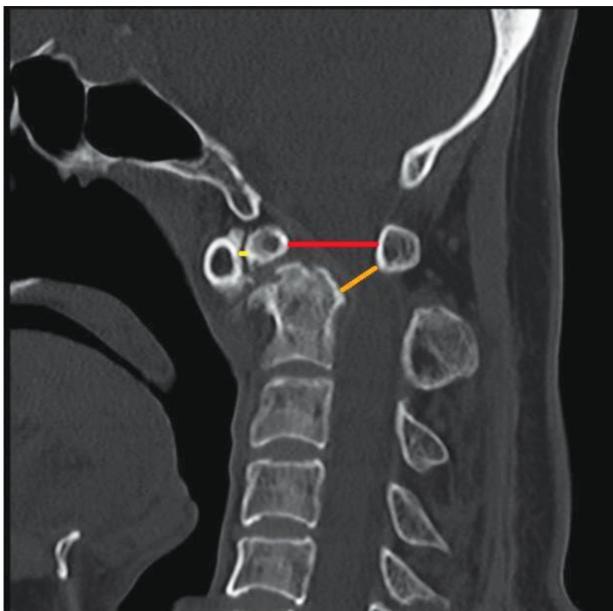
Radiographic parameter
